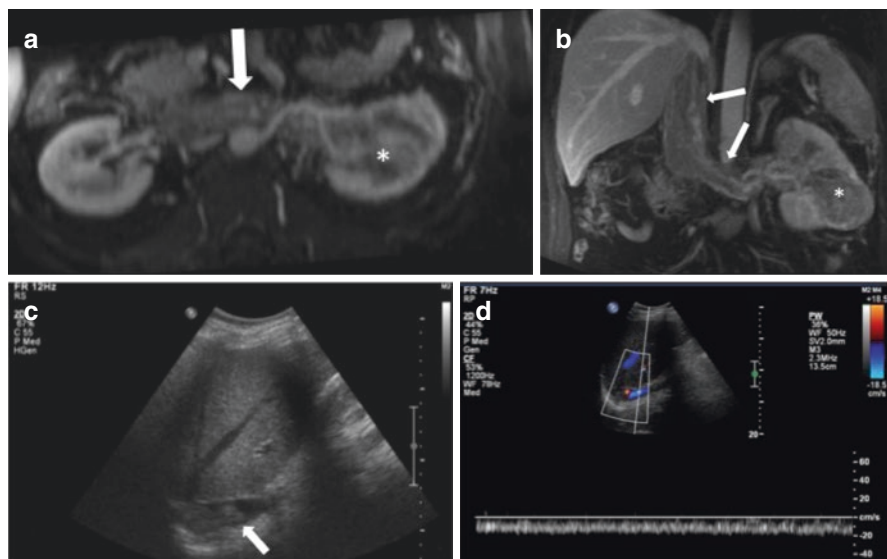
Clear cell renal cell carcinoma. Hypervascular infiltrative solid mass in the middle-third of the left kidney (*), with renal sinus invasion and enhancing tumor thrombus in the renal vein extending into the inferior vena cava until the level of the diaphragm (arrows), on volumetric axial (a) and coronal (b) post-contrast MR images. US confirmed the presence of a thrombus inside the IVC (arrow in c), with presence of flow on Doppler (d), conforming its tumor nature
